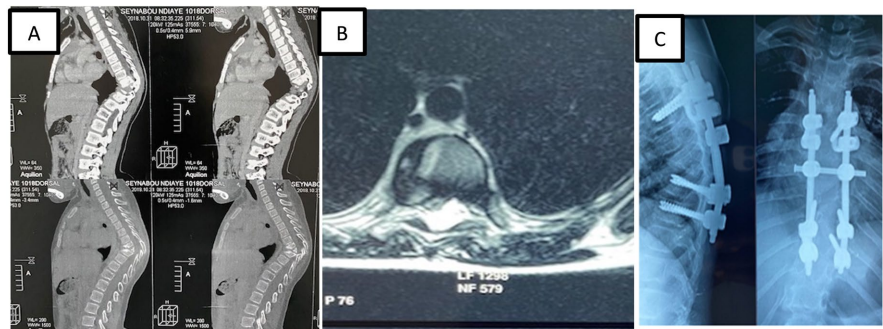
(A) Sagittal section CT scan of the spine and (B) Axial section MRI showing a discovertebral osteolytic lesion suggestive of dorsal spondylodiscitis at the level of D9-D10 with significant kyphosis and compressive epiduritis on the spinal cord, (C) Post-operative fixation radiograph.
